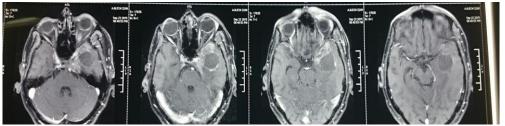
CT brain consract image showing
